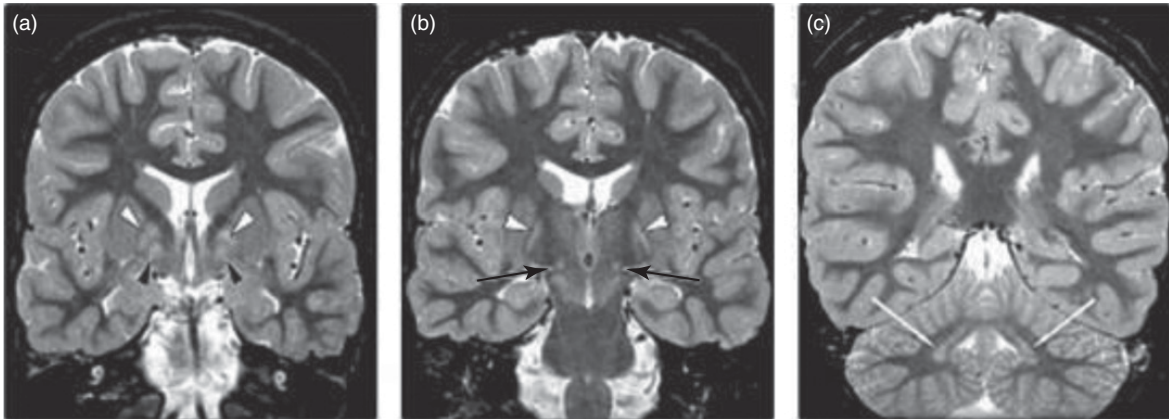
Dentato-pallido-luysian pattern in SSADH deficiency. Coronal short tau inversion recovery sections from MRI in a patient with SSADH deficiency showing bilateral symmetrical homogenous signal abnormalities in the globus pallidus (internal portion [black arrows, a], external portion [white arrows, a and b]), subthalamic nucleus (black arrows, b), and dentate nucleus (white arrows, c). Reproduced with permission from Pearl PL, Gibson KM, Quezado Z, Dustin I, Taylor J, Trzcinski S, et al. Decreased GABA-A binding on flumazenil PET in succinic semialdehyde dehydrogenase deficiency. *Neurology*. 2009;73(6):423–9.
